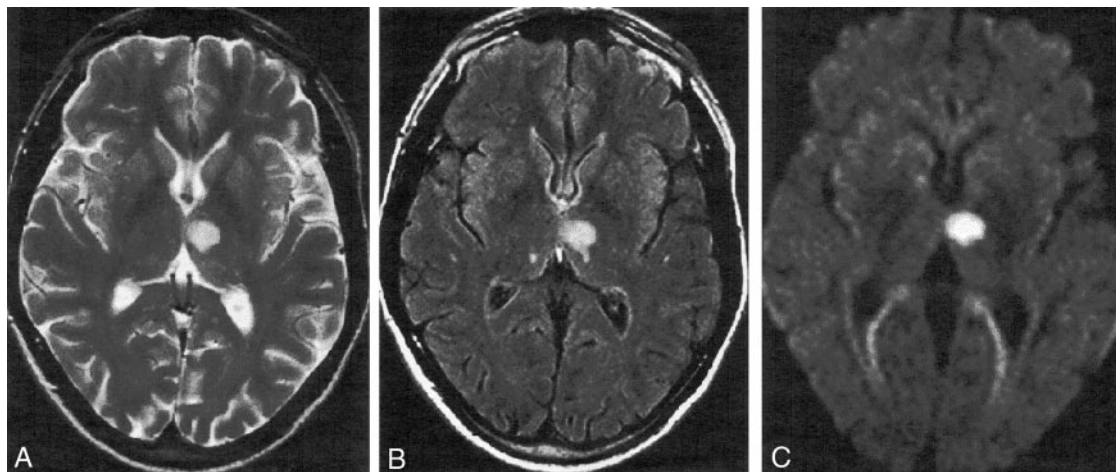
Axial MR images obtained in a 40-year-old man with transient right hemiparesis 5 days after onset of symptoms.
